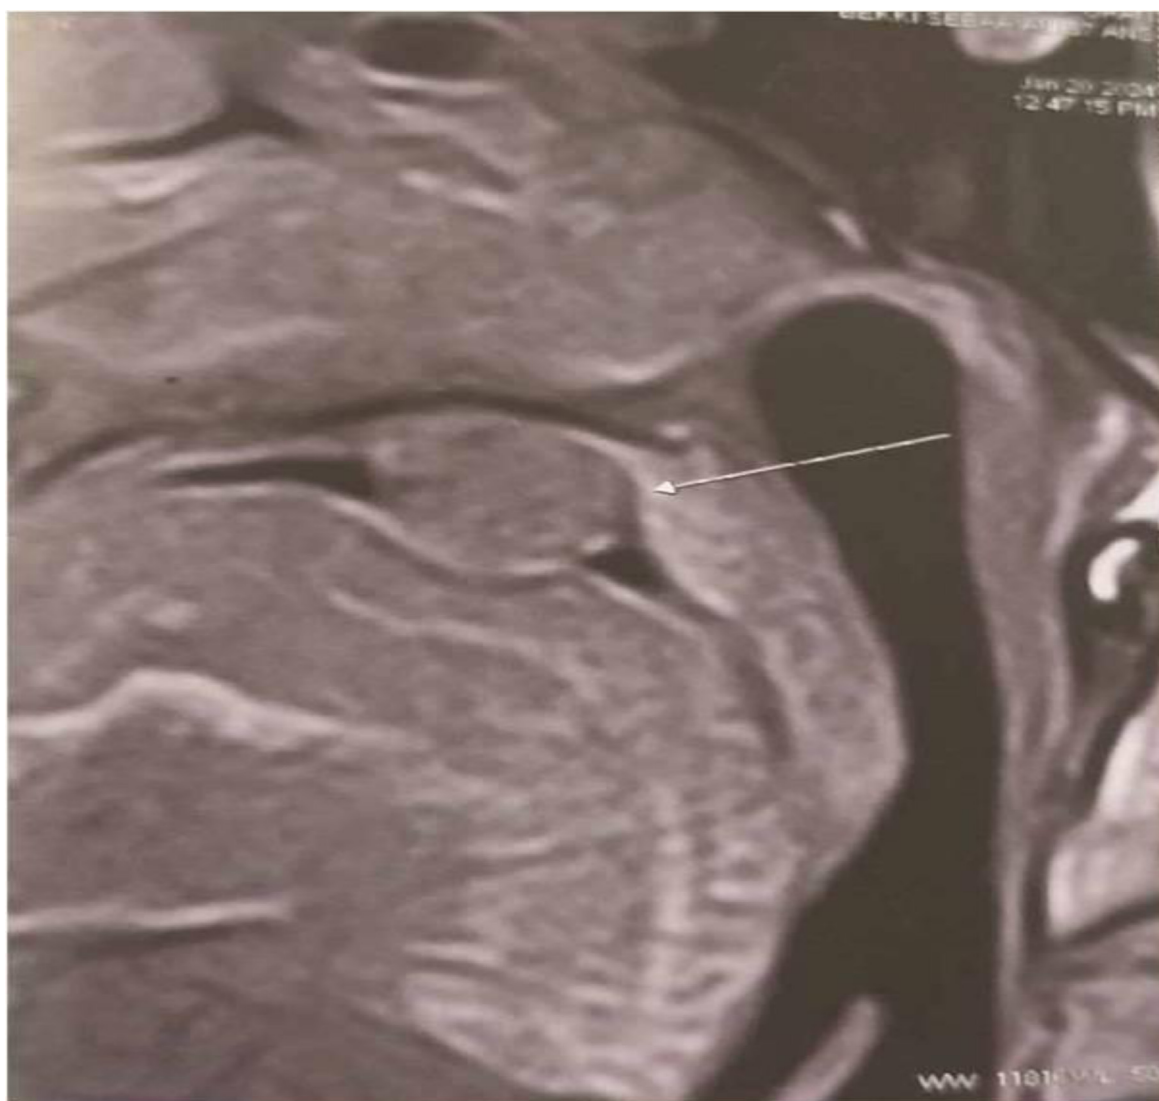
MRI demonstrating contrast uptake and osseous scalloping.
